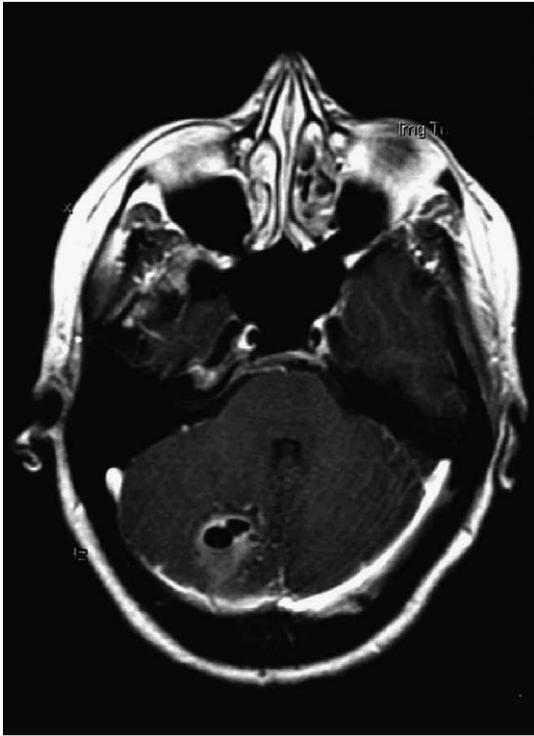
MRI axial T1-weighted (TR = 400, TE = 26), post-gadolinium contrast exam through the posterior fossa demonstrating a biloculated rim enhancing lesion with an associated mass posteriorly within the right cerebellum, consistent with a metastasis.
